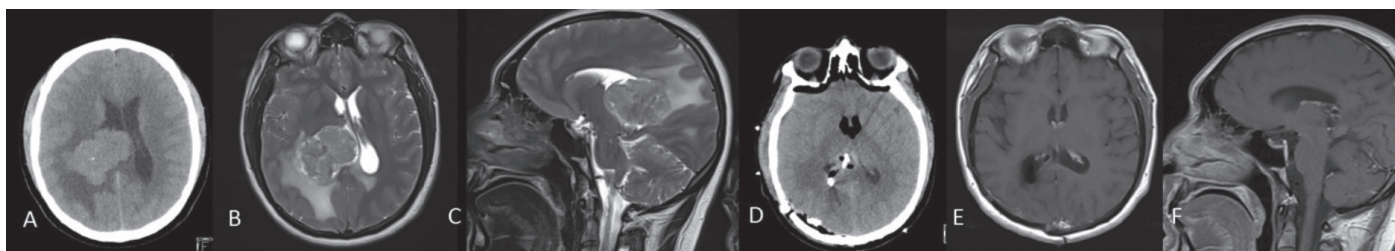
Preoperative brain computed tomography (CT) (A) showing a 60x45 mm ventricular tumor extending to the left of the midline on right lateral ventricle posterior horn. T1W axial (B), and sagittal (C) cranial magnetic resonance imaging (MRI) demonstrating intense contrast enhancing tumor and causing 6 mm shift in the midline. Postoperative 1. day brain CT (D) showing total resection of the tumor. Axial (E), and sagittal (F) cranial MRI two years after the surgery, no residual or recurrent lesion was observed
